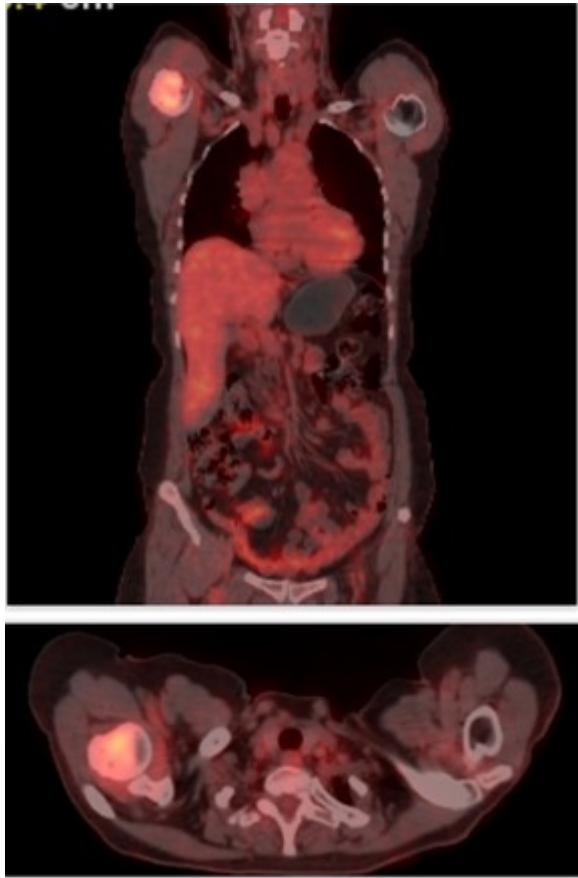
Axial and Coronal PET-CT image showing increased fluorodeoxyglucose uptake in the proximal right humerus, indicative of a metabolically active metastatic lesion.
